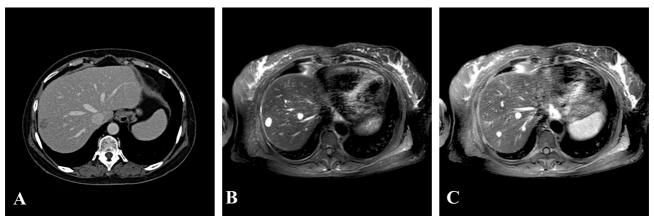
CT (a) and MRI (b, c) findings when DG chemotherapy was finished. Multiple liver metastases are seen.
